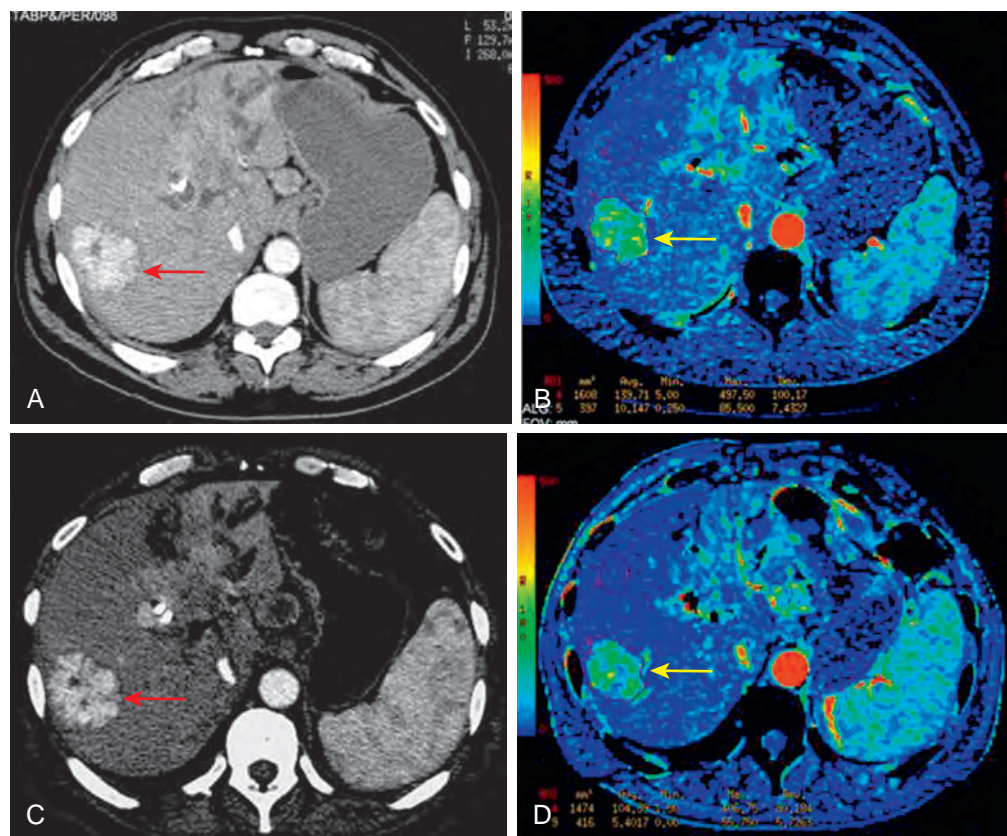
Liver metastasis. A and C. CT perfusion images before and after antiangiogenic treatment in a 53-year-old man with liver cancer (arrow). B. Colored perfusion map of blood flow (arrow) at baseline before antiangiogenic treatment shows a high tumor blood flow (140 mL per 100 g/min). D. Colored perfusion map after treatment shows a reduction in tumor blood flow (104 mL per 100 g/min). On contrast-enhanced CT images (A and C), the lesion appears stable by size.
